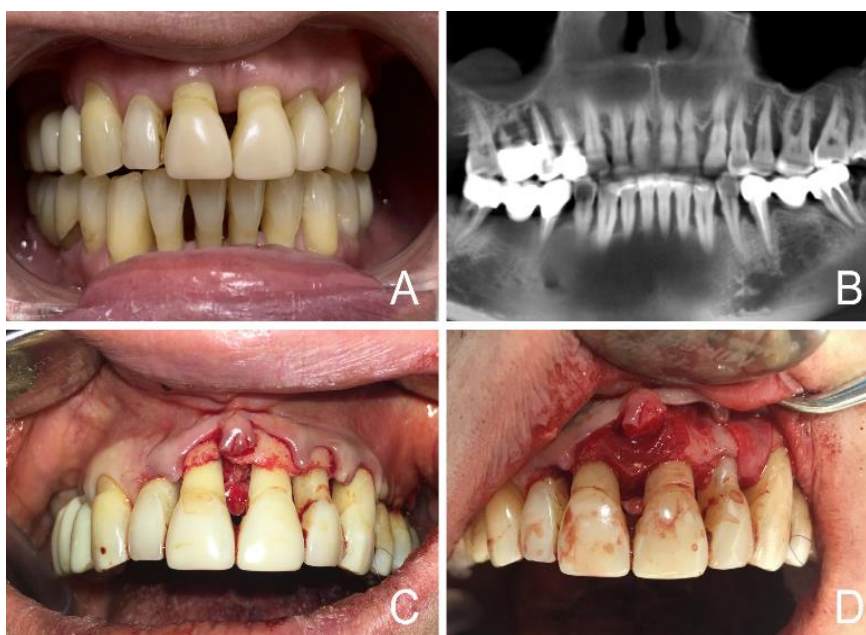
A. The situation after initial periodontal treatment. B. CBCT screenshot. Deep bony craters are visible both on upper and lower jaws. C. Regenerative periodontal surgery on the upper jaw. D. Bony craters are filled with bone substitute and covered with collagen membrane.
